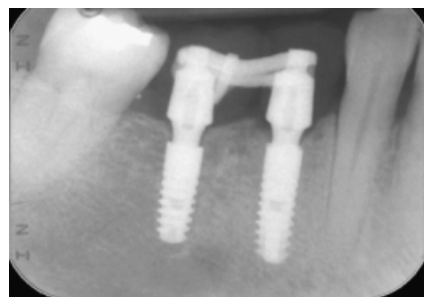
Test case: periapical radiograph taken immediately after surgery.
